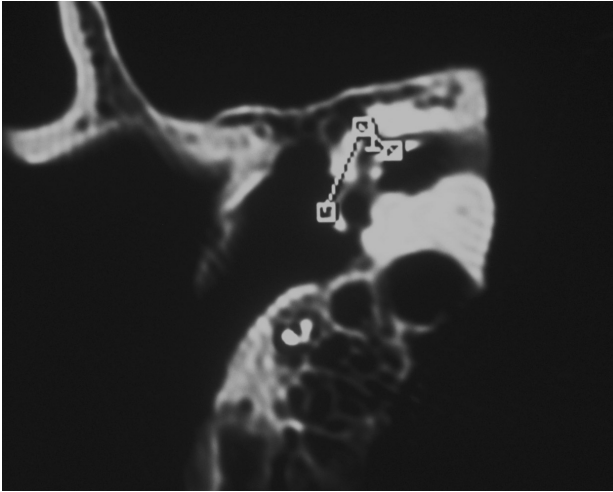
The angle of between LS and tympanic segment of the FN on the axial temporal bone HRCT scan.
